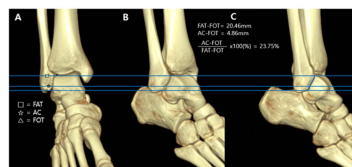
The position of the fibula tunnel for the knotless anchor was measured by reconstructing the 3D image after marking the location of the tunnel using the lateral view. (A) FAT, FOT, and the position of the anchor tunnel were identified on the CT scan. (B and C) The 3D-CT scan image was rotated until a true lateral view was obtained. Next, the ratio of the distance between AC and FOT, and FAT and FOT were measured. FAT, fibular anterior tubercle; FOT, fibular obscure tubercle; AC, anchor.
